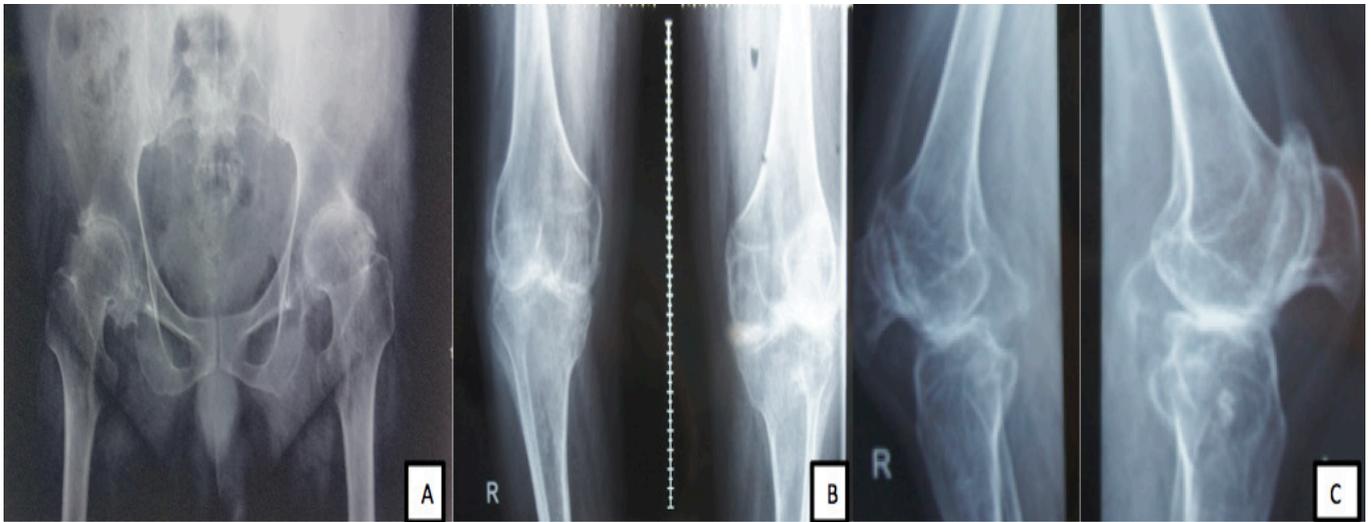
(A) Anteroposterior radiograph of the pelvis showing end stage arthritis of both the hips joints (B) Anteroposterior radiograph of both the knees showing end stage arthritis of both the knee joints (C) Lateral radiograph of both the knees showing end stage arthritis of both the knee joints.
